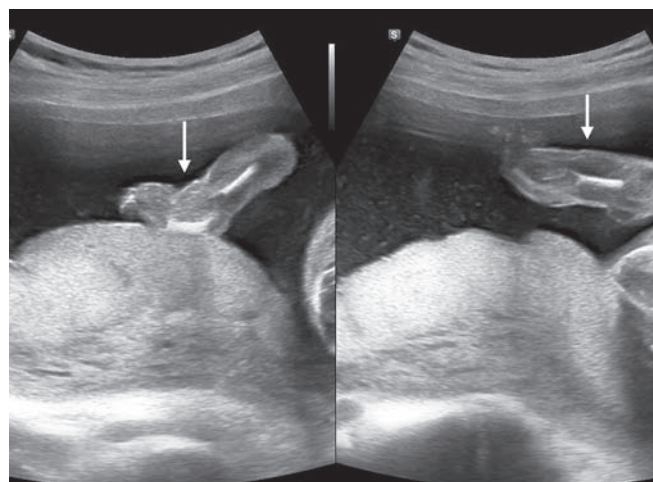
Ultrasound image for estimating growth of limb
